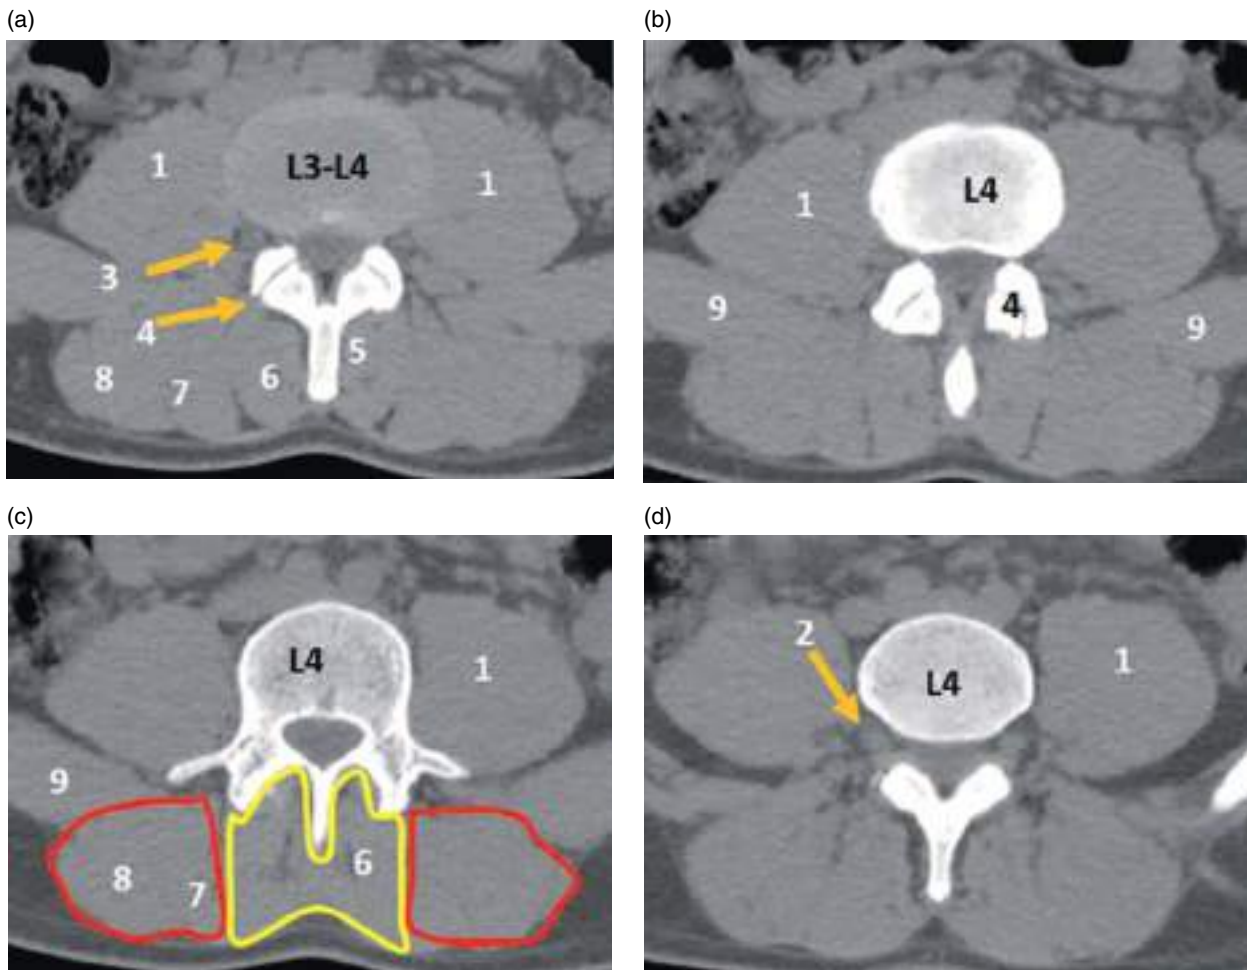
Axial CT image at the level of the L3–L4 disc (a), L4 lateral recesses (b), L4 pedicles (c), and L4 foramina (d). 1, psoas muscle; 2, L4 nerve root; 3, L3 nerve root; 4, facet joint; 5, rotator muscles; 6, multifidus muscle; 7, longissimus muscle; 8, iliocostalis muscle; 9, quadratus lumborum muscle; yellow line, transversospinalis muscles; red line, erector spinae muscles.
